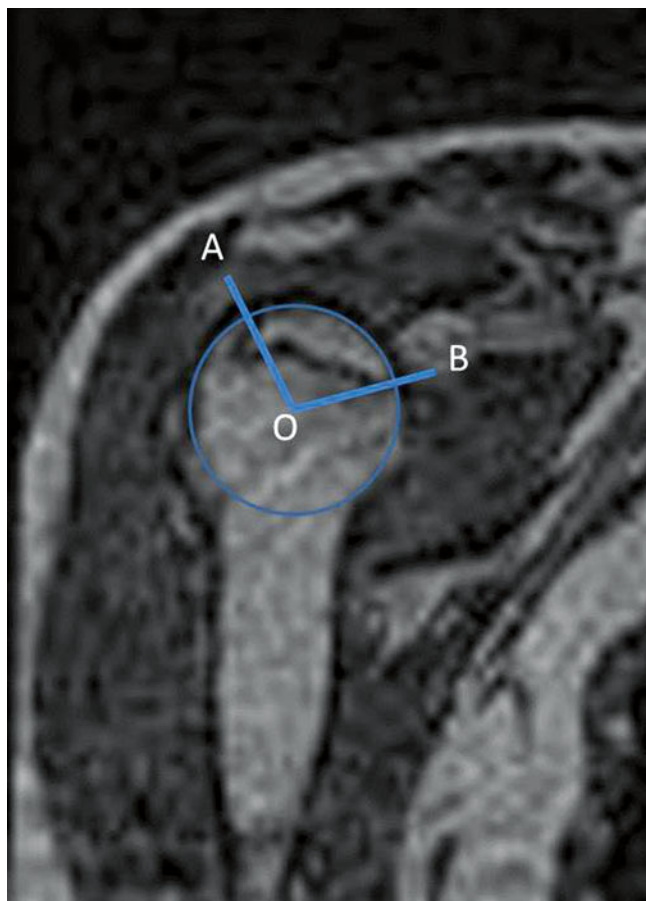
The necrotic angles of ONHH on MRI. The center of the humeral head was defined as point *O*, and two end points of the necrotic lesion on the joint surface were defined as points *A* and *B* on mid-oblique-coronal and mid-oblique-sagittal SPGR images of the humeral head. The necrotic angle was calculated as the angle *AOB*
